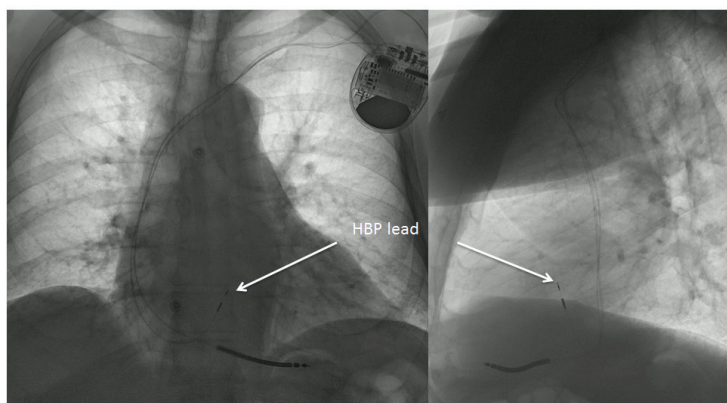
PA and lateral chest X-rays of patient in figure 1 is shown.
